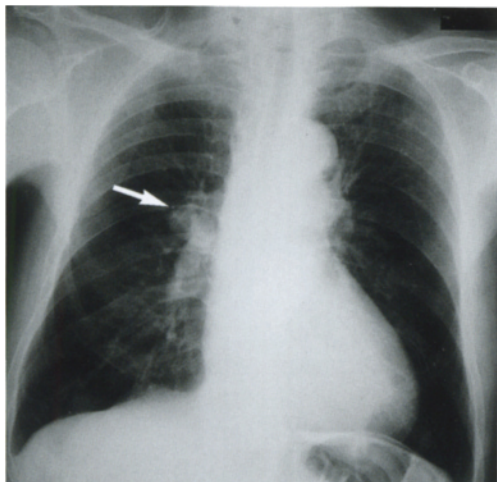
A PA chest radiograph reveals a small number of q-size small rounded opacities in both upper lung zones. A larger nodule is noted in the right hilar area (*white arrow*). The ILO classification is 1/1 q/q, ca
